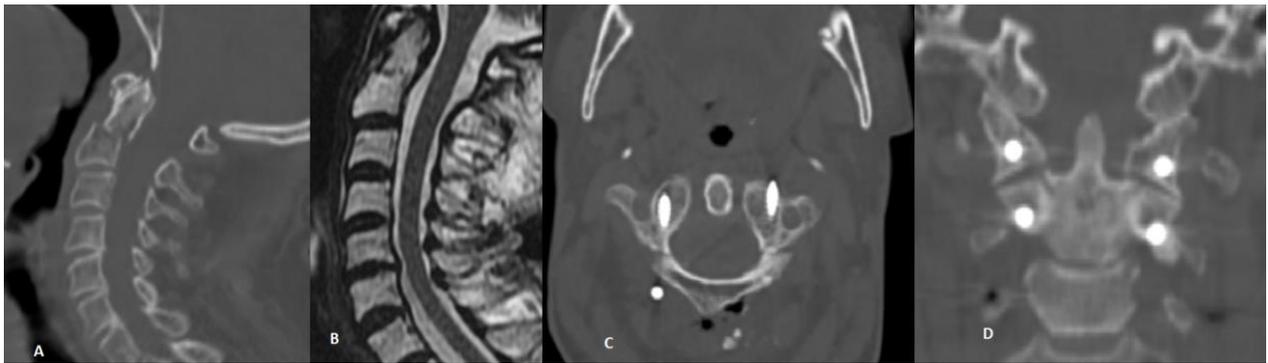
A: Sagittal CT image of Type 2 odontoid fracture, B: Preoperative T2 Cervical MR image, C: C1 lateral mass screw image on postoperative cervical CT axial plane, D: C1-2 lateral mass screw image on postoperative cervical CT coronal plane.
